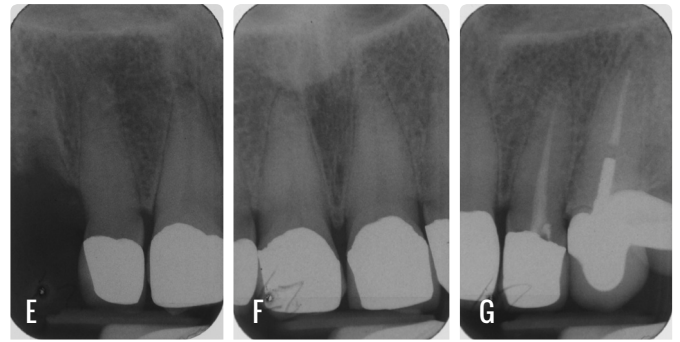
Peri-apical radiograph of UR1 and UR2
